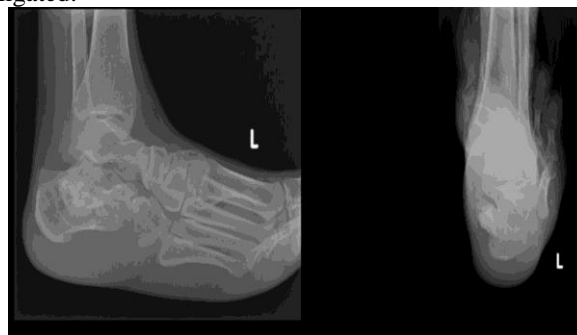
X-ray images showing focal calcific lesion noted on the medial aspect of the left calcaneum with scalloping of the calcaneum
